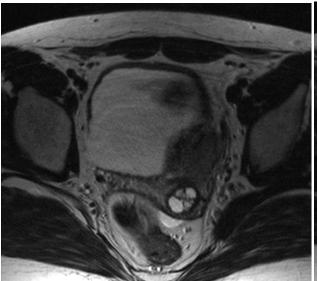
Pelvic MRI: left ovary dermoid cyst.
